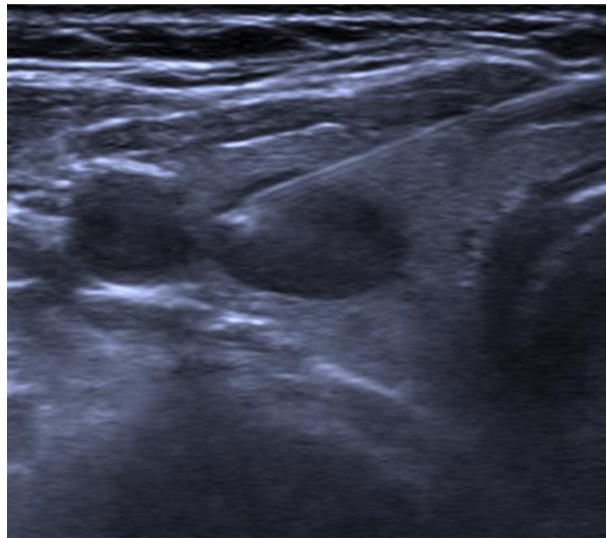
Ultrasound-guided FNAC: the tip of the needle is placed inside the lesion assuring the optimal cytologic sampling.
